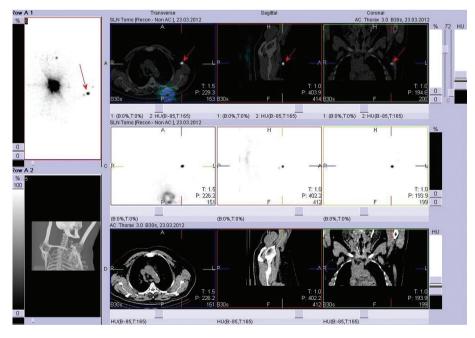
The same patient as in the Figure 1. Fusion of SPECT and CT. Exact localization of SLN in the left axilla
